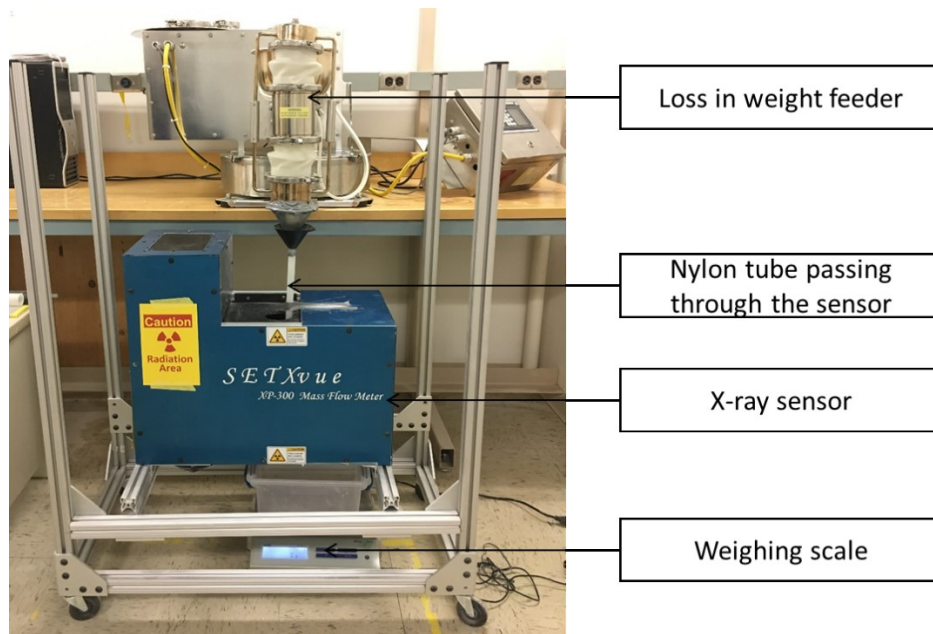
Off-line setup of the x-ray sensor for understanding the usability for inline mass flow rate monitoring in a continuous tablet manufacturing line
